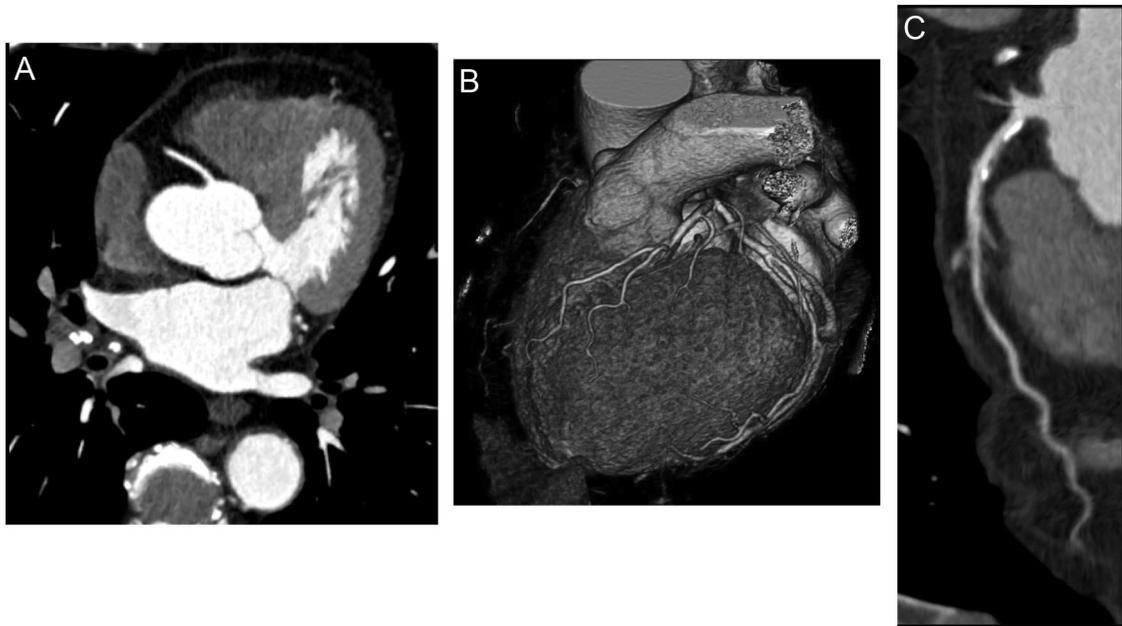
Coronary CTA with iomegon 400 (80 mL, 5 mL/s) of a 70-year-old man (BMI, 26.3 kg/m²) with high coronary arterial enhancement (mean, 482–524 HU), and excellent quality scores (5 of 5, for all 3 readers) for vessel visualization and diagnostic confidence. The readers assessed 17, 17, and 16 vessel segments, respectively, out of 17 as adequately delineated. A, axial slice; B, VR image; C, curved multiplanar reformat of the LAD artery. Note that due to the high contrast, the window width and level could be increased (1000 HU, 300 HU) with an excellent depiction of calcified and noncalcified plaques.
